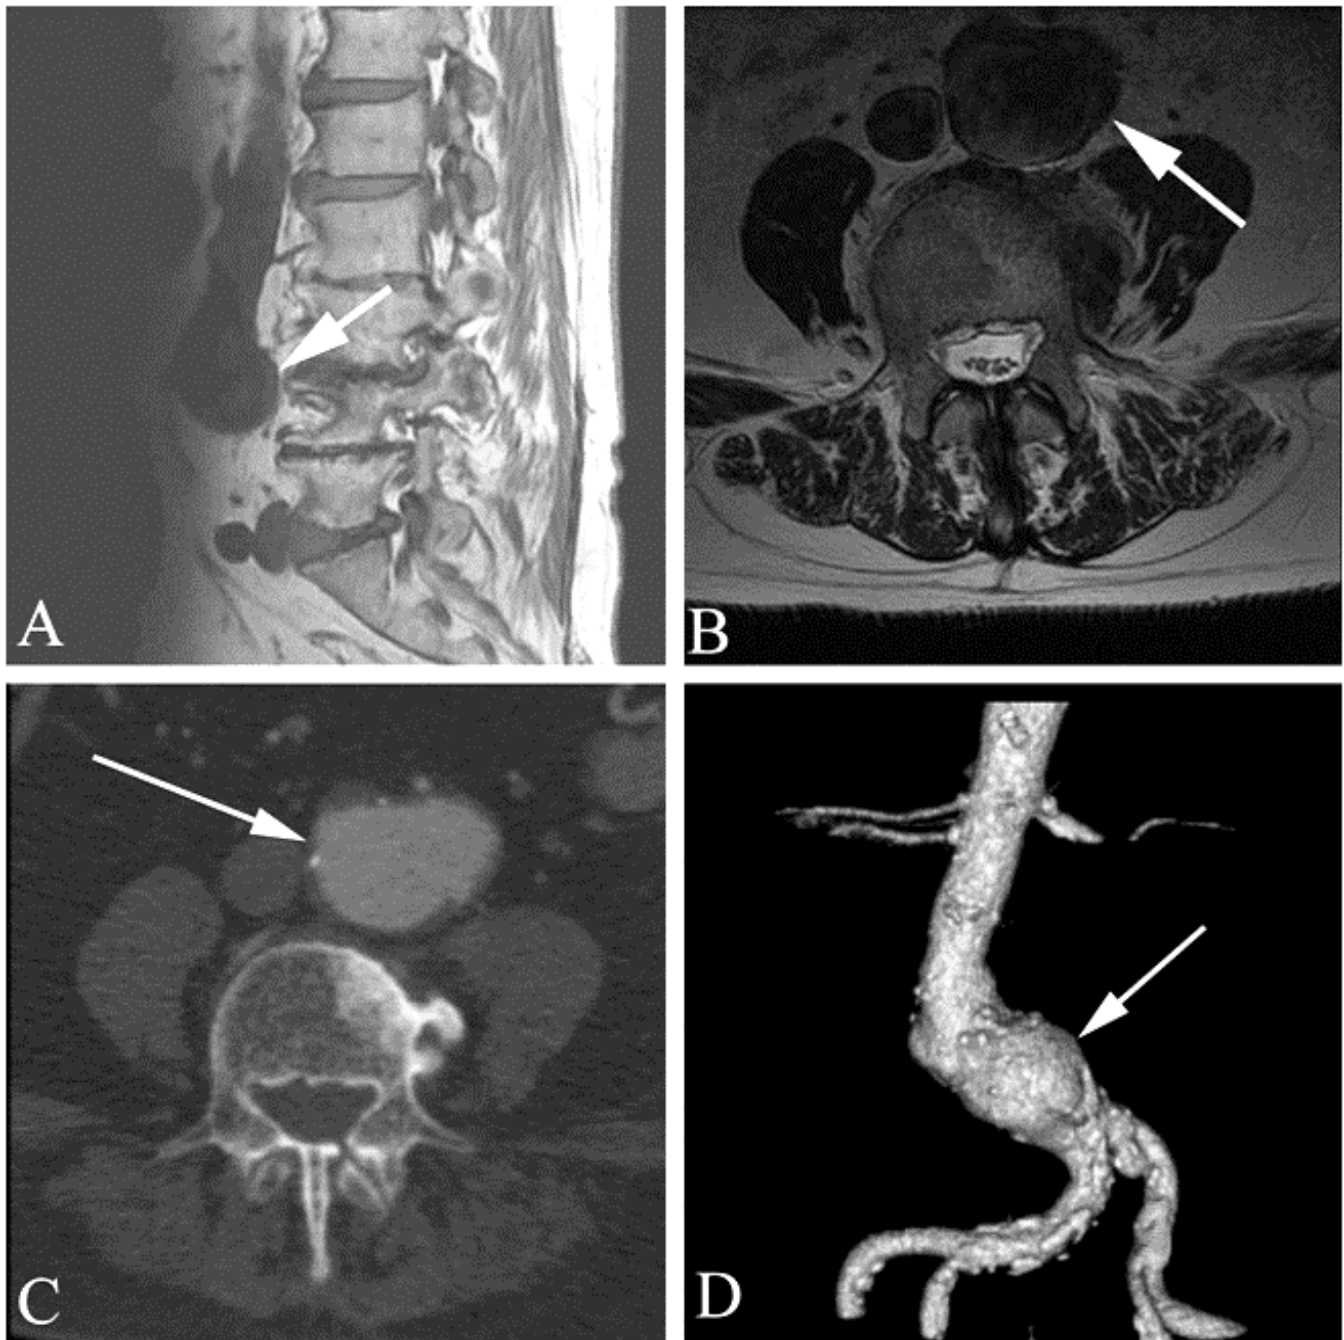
Abdominal aortic aneurysm incidentally discovered in a 74 year old with back pain undergoing lumbar spine MR study. A. Sagittal T1 weighted lumbar spine MR study shows an aneurysm of the lower abdominal aorta (arrow). B. Axial T2 weighted MR image through the L4 vertebral body level shows the aneurysm anterior to the lumbar spine (arrow). C. Contrast-enhanced axial CT angiogram shows the abdominal aortic aneurysm (arrow). D. Surface rendering based on CT data of the aneurysm, showing the location along the distal infrarenal abdominal aorta (arrow).
